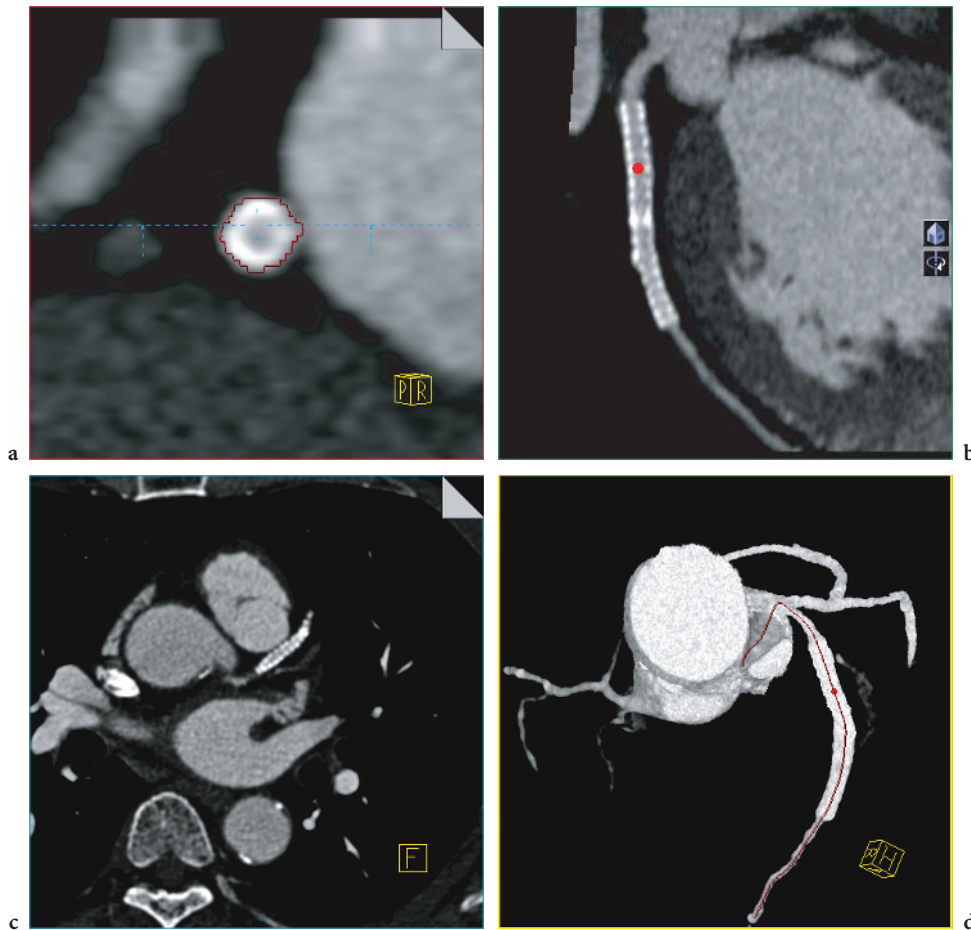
Example of a modern software-evaluation platform for automated segmentation and analysis of the coronary arteries based on an examination obtained on a 64-slice CT scanner with acquisition of 64×0.6 -mm slices per rotation. d VRT visualization of the segmented coronary artery tree including the centerline (indicated in red) along the LAD is used for an overview. b An additional double-oblique MIP in the LAO helps to localize the exact position of the stent. c A curved MPR along the centerline allows for excellent visualization of the stent lumen due to isotropic sub-millimeter resolution. a A cross-section perpendicular to the centerline at the position indicated by the red marker allows for accurate measurement of the lumen. (Case courtesy of Erasmus University, Rotterdam, Netherlands)
